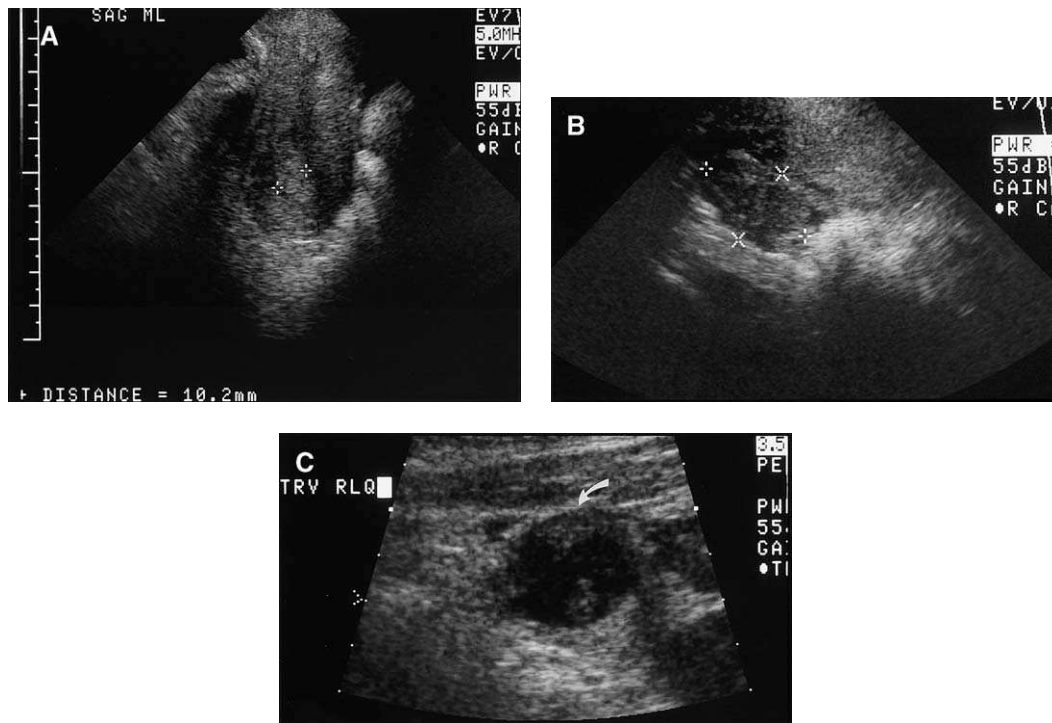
(A) Endovaginal ultrasound shows a sagittal view of the uterus with a normal appearing endometrial stripe marked by calipers. (B) Normal right ovary marked by calipers. (C) Transabdominal ultrasound of the right lower quadrant shows a complex mass (arrow) high in the pelvis that contains a yolk sac and fetal embryonic pole, consistent with ectopic pregnancy.
